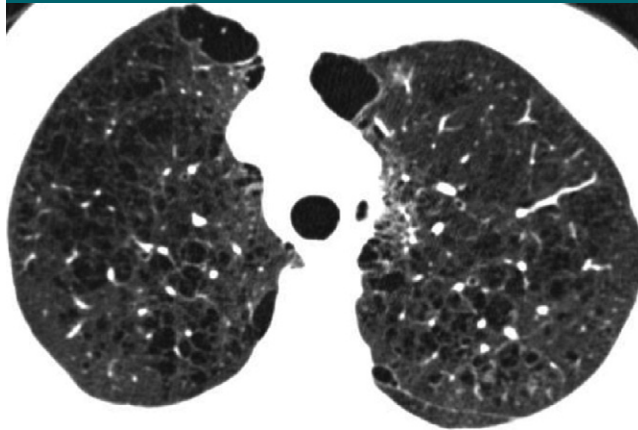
Moderate CLE. CT scan in patient with GOLD stage I COPD shows many well-defined centrilobular lucencies that occupy more than 5% of upper lung zone. PSE is seen in antero-medial right and left lungs.
